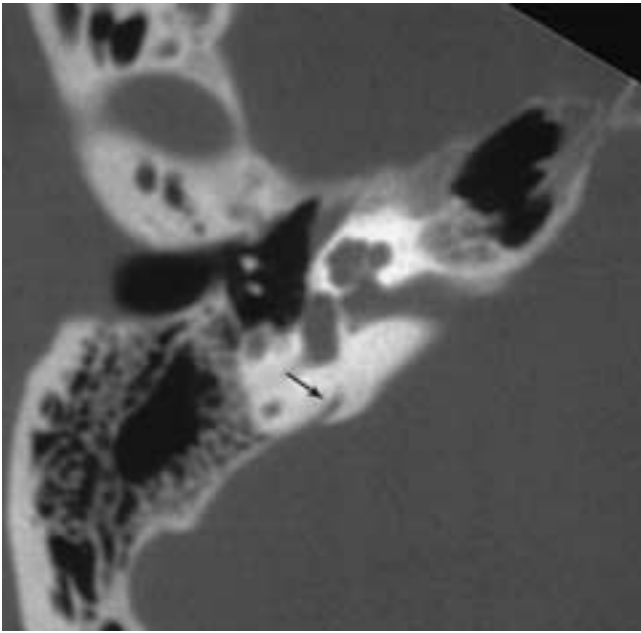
Pseudofracture, vestibular aqueduct. Note the focal intrusion into the posterior cortex of the petrous bone (*arrow*) at this location on this magnified axial CT image of the right ear. This is the normal appearance of the vestibular aqueduct in the axial plane.
